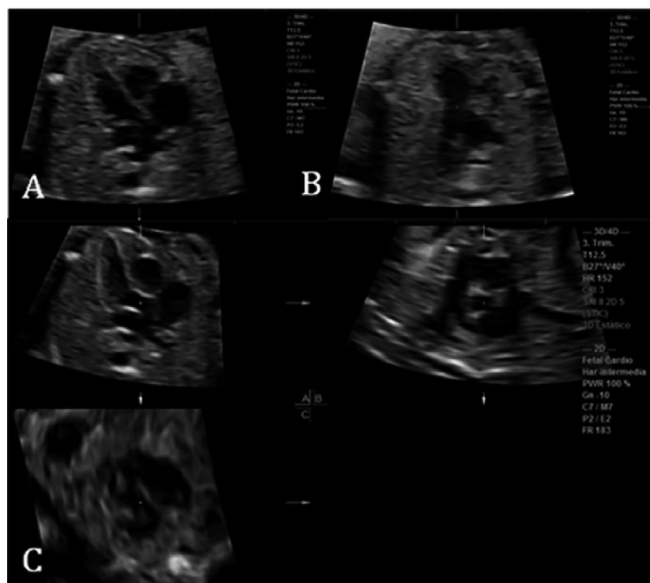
Images for evaluating the fetal cardiac screening by four-dimensional ultrasonography with spatiotemporal image correlation (STIC) by multiplanar mode. A: four-chamber view of the fetal heart. B: three-vessel view of the fetal heart. C: left ventricular outflow tract (LVOT) and right ventricular outflow tract (RVOT)
